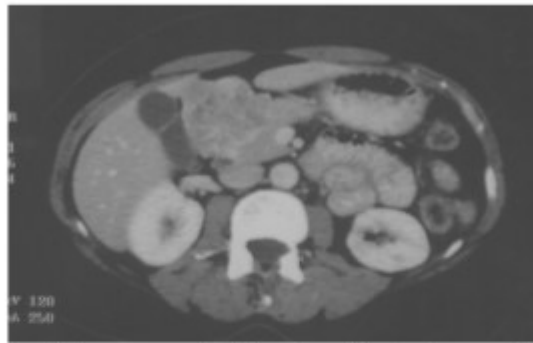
CT scan image showing a large lobulated mass with well-defined margins, arising from the first and second parts of the duodenum.
